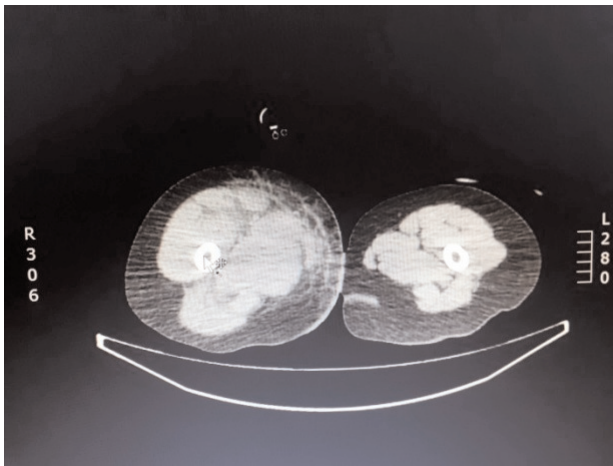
CT showing right leg subcutaneous emphysema, fat infiltration with intramuscular fluid collection
